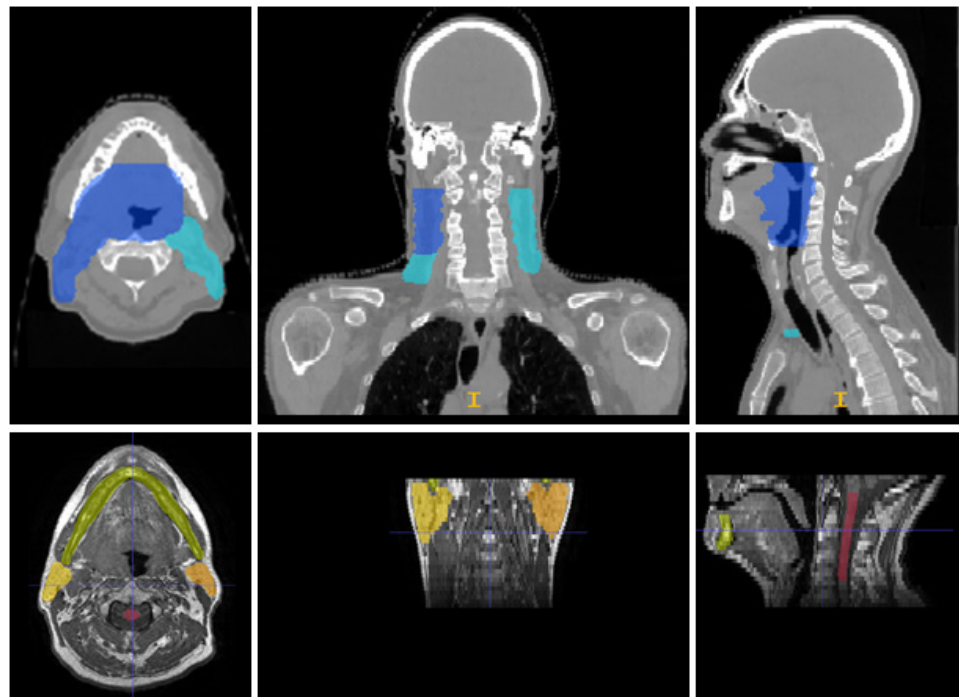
This figure depicts axial, coronal and sagittal slices of the CT (top row) and MR (bottom row) images of one example patient from the database used in this study. The coloured regions represent the manual segmentations of the primary planning target volume (PTV) (blue) and the secondary PTV (turquoise) on the CT, as well as the left (orange) and right (yellow) parotids, the mandible (green) and the spinal cord (red) on the MR images.
